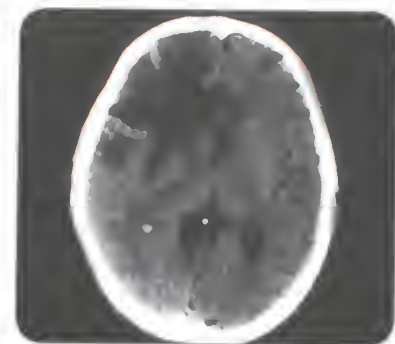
CT scan showing intracerebral brain haemorrhage.
